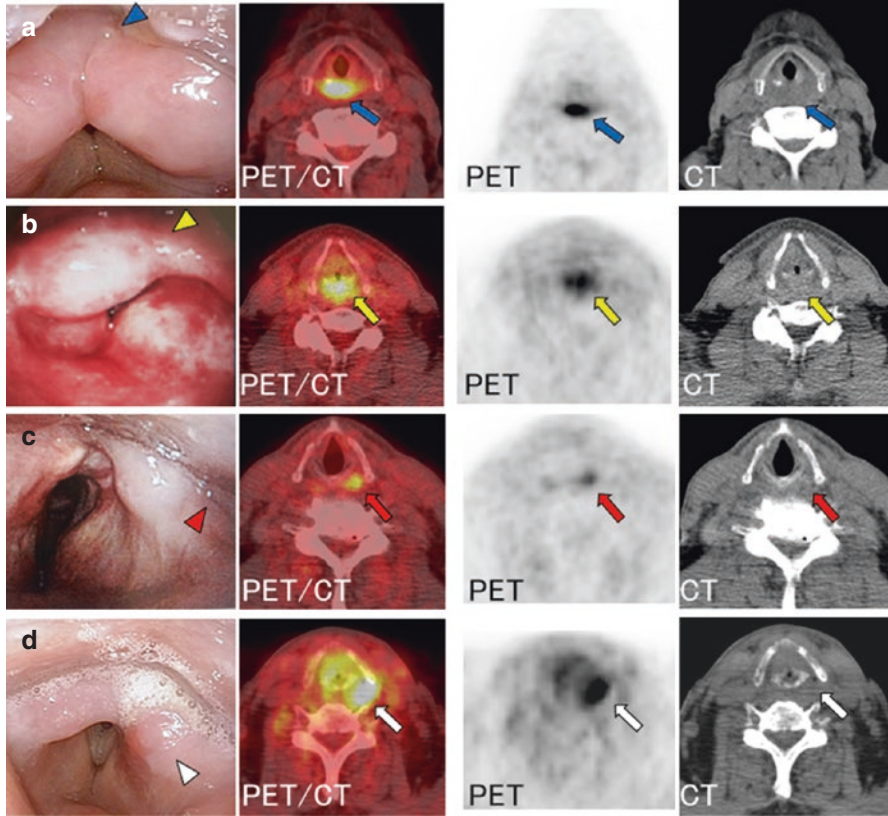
All cases in a–d involved patients with hypopharyngeal SCC who underwent definitive radiotherapy with or without chemotherapy. PET/CT and fiberoscopy were performed 3 months after the completion of therapy for evaluation of the treatment response. Moderate to intense FDG accumulation suggesting the existence of a residual tumor (arrows) can be seen on PET/CT; however, apparent residual tumors cannot be observed during fiberoscopy because of moderate to severe laryngopharyngeal edema in each case (arrowheads). Cases a–c exhibit false-positive PET/CT findings. In cases a and b, FDG shows diffuse accumulation in the postcricoid region [maximum standardized uptake value (SUV_{max}), 6.1 and 3.8, respectively]. In case c, FDG shows focal accumulation in the left pyriform sinus (SUV_{max}, 3.6). These false-positive findings were caused by persistent radiation-induced mucositis. Only Case d shows true-positive findings on PET/CT. Intense FDG accumulation (SUV_{max}, 9.9) can be observed in the left pyriform sinus around the edematous laryngopharyngeal region, which shows diffuse/moderate FDG accumulation
